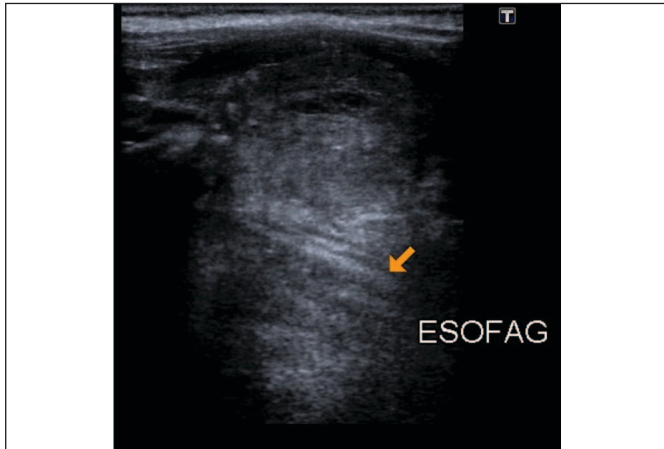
Ultrasound showed the esophageal pathway intact.
